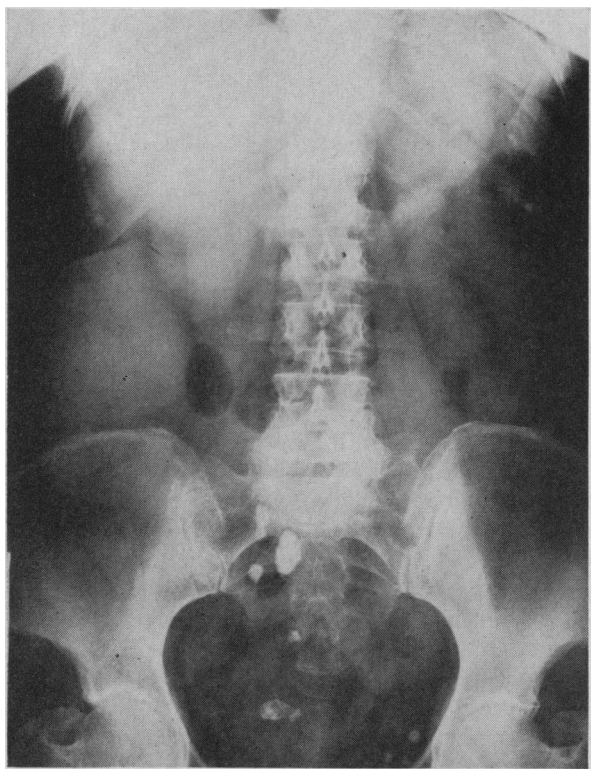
Roentgenogram of the abdomen revealing a large mass on the right side.
